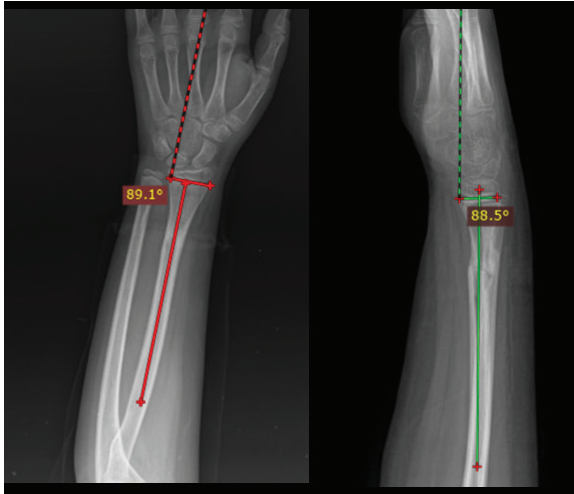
Measurement of angular change on final follow-up radiographs.
